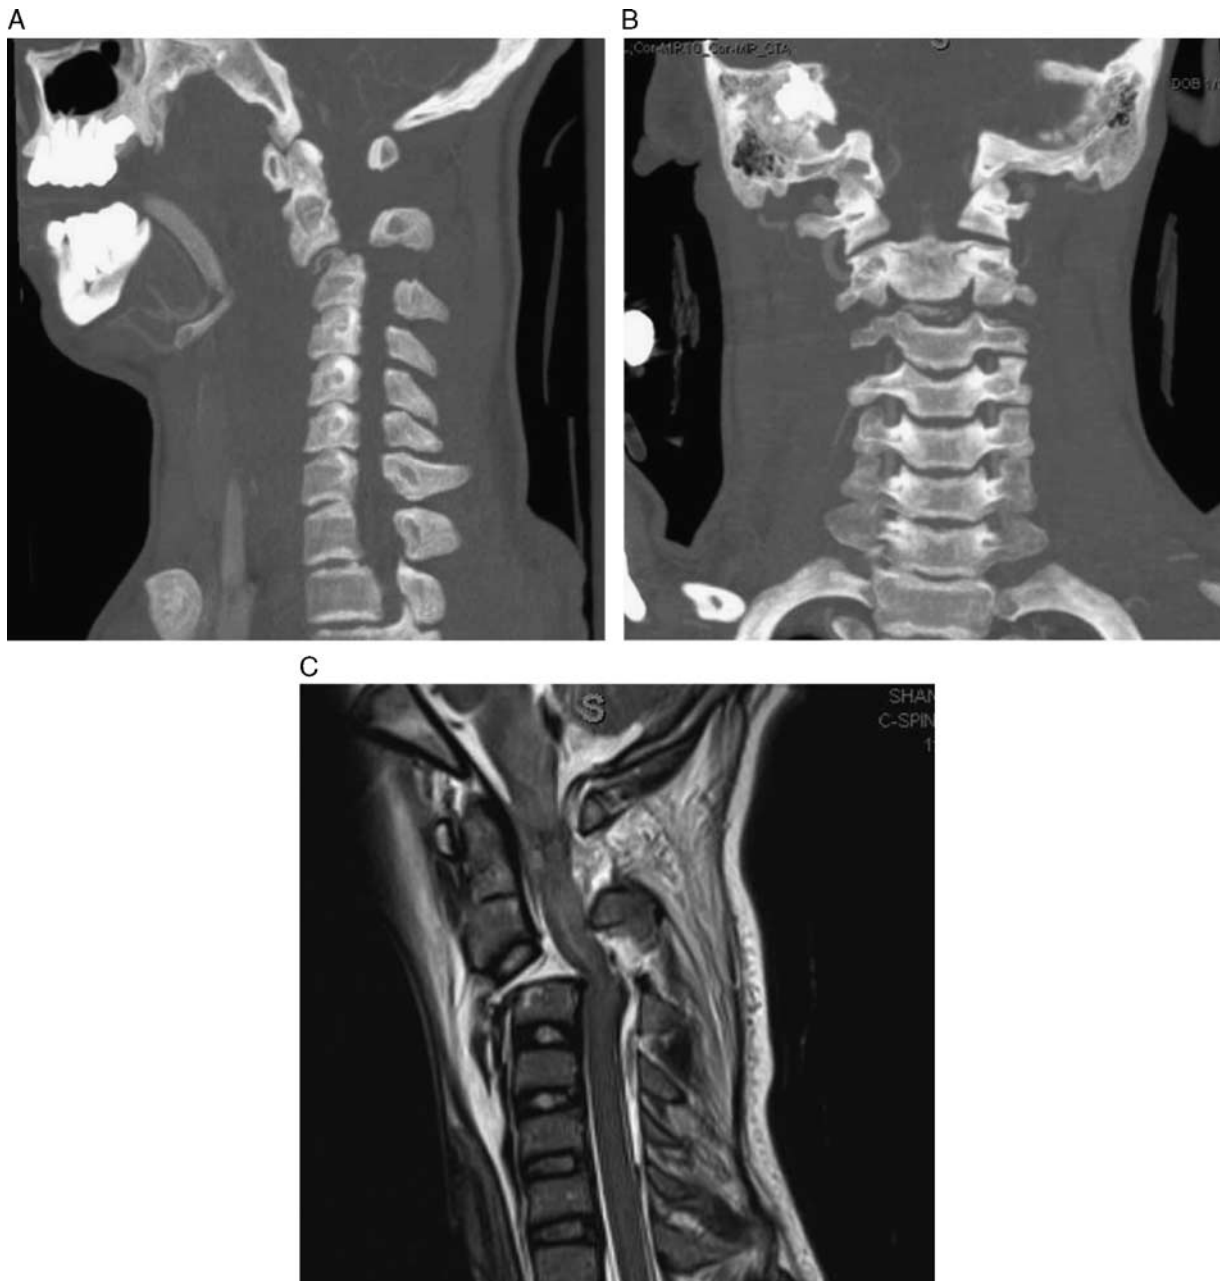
Subject 844—spinal cord injury. A and B, AP and lateral cervical spine radiographs of a C2-C3 fracture with listhesis and canal narrowing in a 16-year-old motocross rider. C, Sagittal MR demonstrating C2-C3 listhesis with canal narrowing and substantial cord edema.
